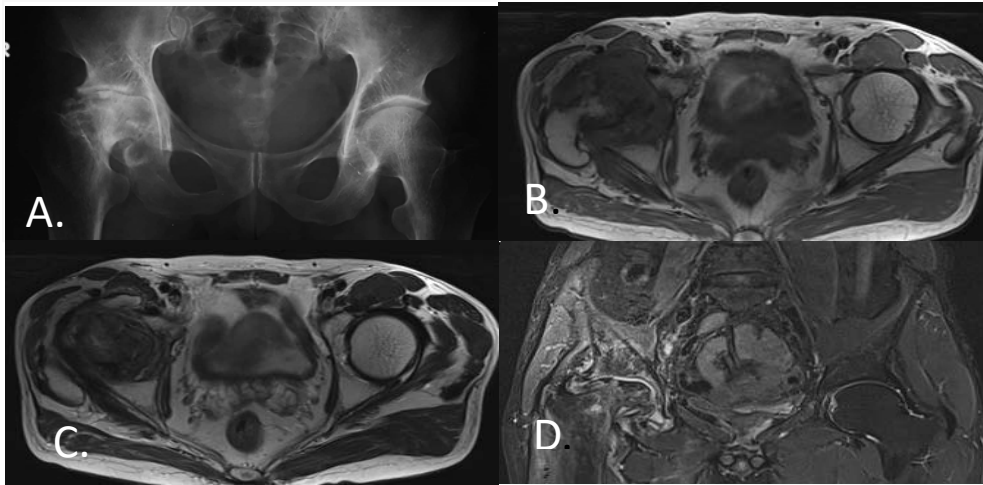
This is Ap radiograph pelvis(A) showing reduced joint space and collapse of right femoral head with secondary osteoarthritic changes. (B,C) MRI T1,T2 axial and (D.) coronal STIR images showing altered signal intensity geographical area involving right femoral head which appears hypointense on T1,T2 and STIR with significant flattening and secondary osteoarthritic changes in femoral head and acetabulum associated with joint effusion and edema- F/S/O right stage IV AVN.
